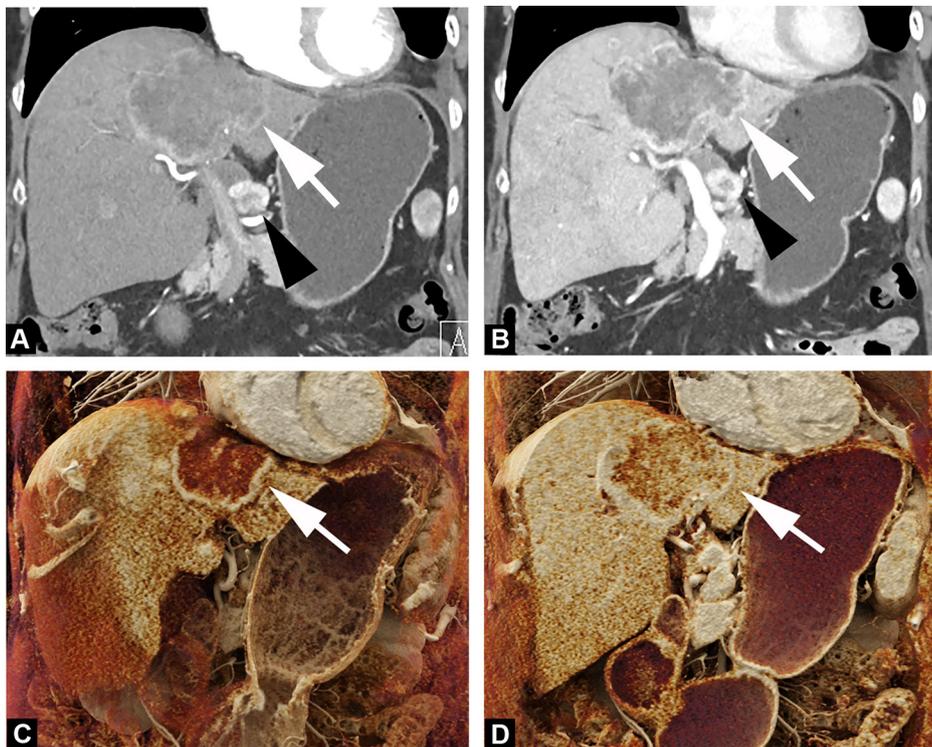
A 75-year-old woman with biopsy proven cholangiocarcinoma. A & B. Two-dimensional CT images obtained in the coronal plane during the arterial (A) and portal venous phase (B) of enhancement show a heterogeneously enhancing mass (arrow) with progressive delayed enhancement (arrow) within the left liver. C & D. CT images obtained in the coronal plane during the arterial (C) and portal venous phase (D) of enhancement with cinematic rendering can accentuate the heterogeneous internal enhancement (arrow) on both arterial and venous phases, an important feature in distinguishing malignant from benign liver masses.
